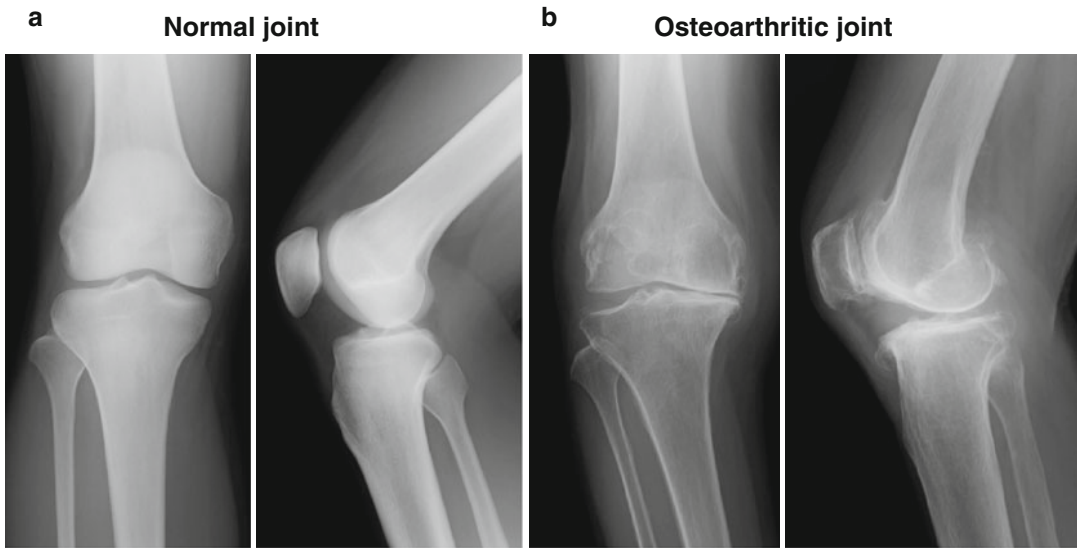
Radiography of (a) normal healthy knee joint and (b) osteoarthritic knee joint. In osteoarthritis, the loss of the cartilage (joint space narrowing) and subchondral
